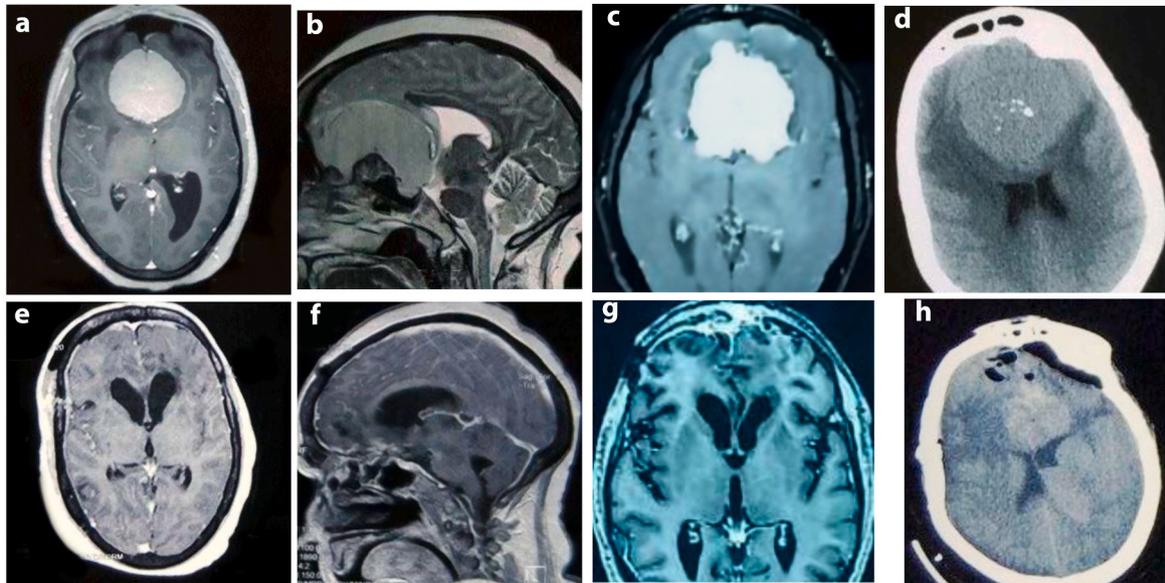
(a,b and c) preoperative and post operative (e, f and g) MRI images of two patients showing large ACF meningioma with edema of bilateral frontal lobes (e, f and g) post-operative MRI with complete tumor resection. Vision improved post-operatively, and olfaction was preserved. (h) post-operative CT Head showing absence of brain contusions and no increase in brain edema c/f pre-operative CT (d).
